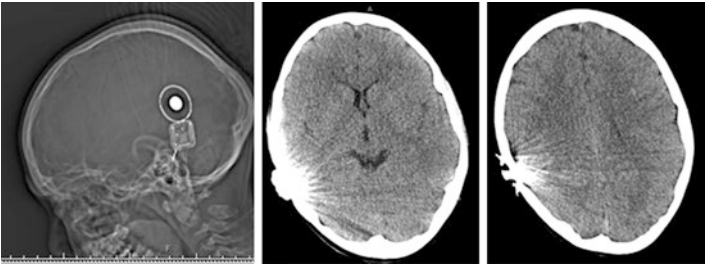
Is a non-contrast CT brain scan from of another patient with a cochlear implant showing no focal abnormality
